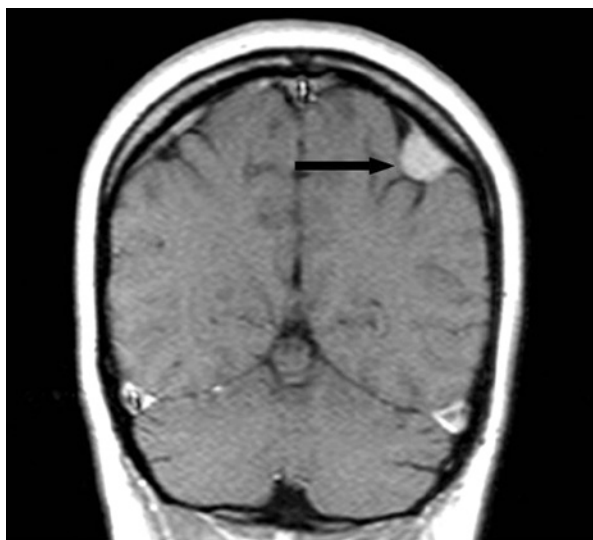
MRI with a right frontal meningioma. MRI, magnetic resonance imaging.
